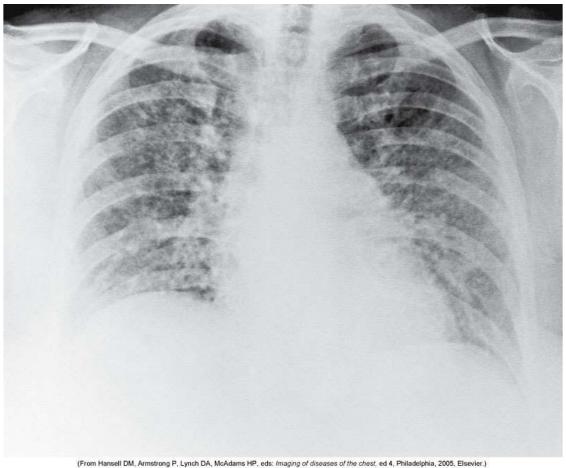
Acute farmer's lung. Chest radiograph shows diffuse parenchymal ground-glass pattern with some areas of consolidation. The severity of parenchymal opacification in this case is unusual.
